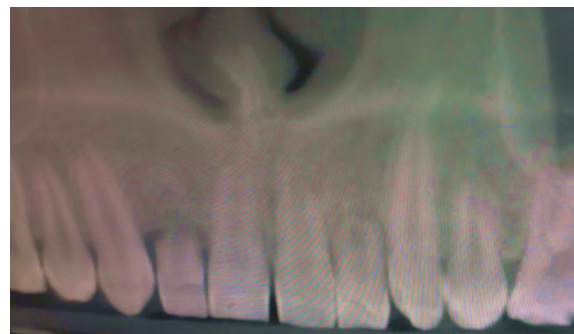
Panoramic view of CBCT of patient
